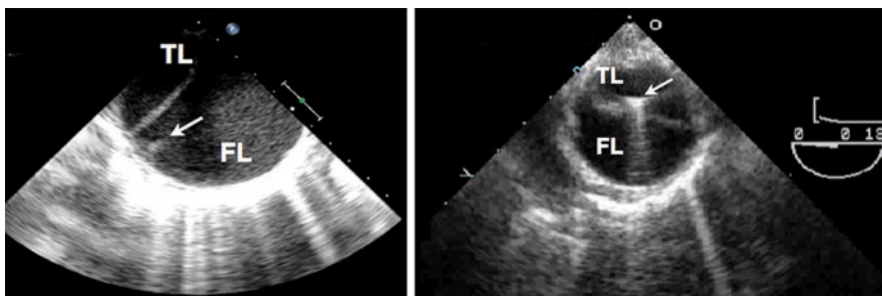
During central aortic cannulation using the Seldinger technique in a patient with aortic dissection, intraoperative transesophageal echocardiography (TEE) imaging of the proximal descending thoracic aorta demonstrated that the guidewire was in the false lumen (FL) of the dissected aorta (left panel). TEE guidance was used to reposition the guidewire into the true lumen (TL) of the aorta (right panel) before insertion of the arterial cannula to prevent cerebral malperfusion upon initiation of cardiopulmonary bypass
